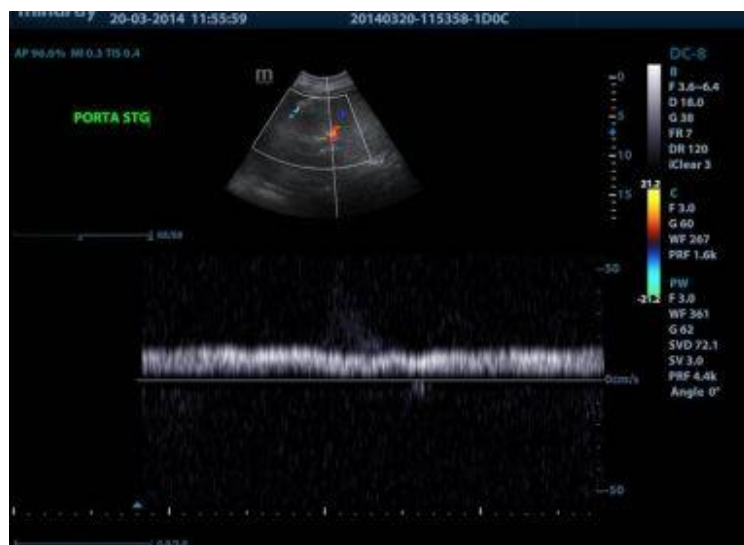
Liver Doppler US – follow-up after embolization: reduced sized PV (14 mm), without thrombosis and normal hepatopetal flow in the left portal branch
